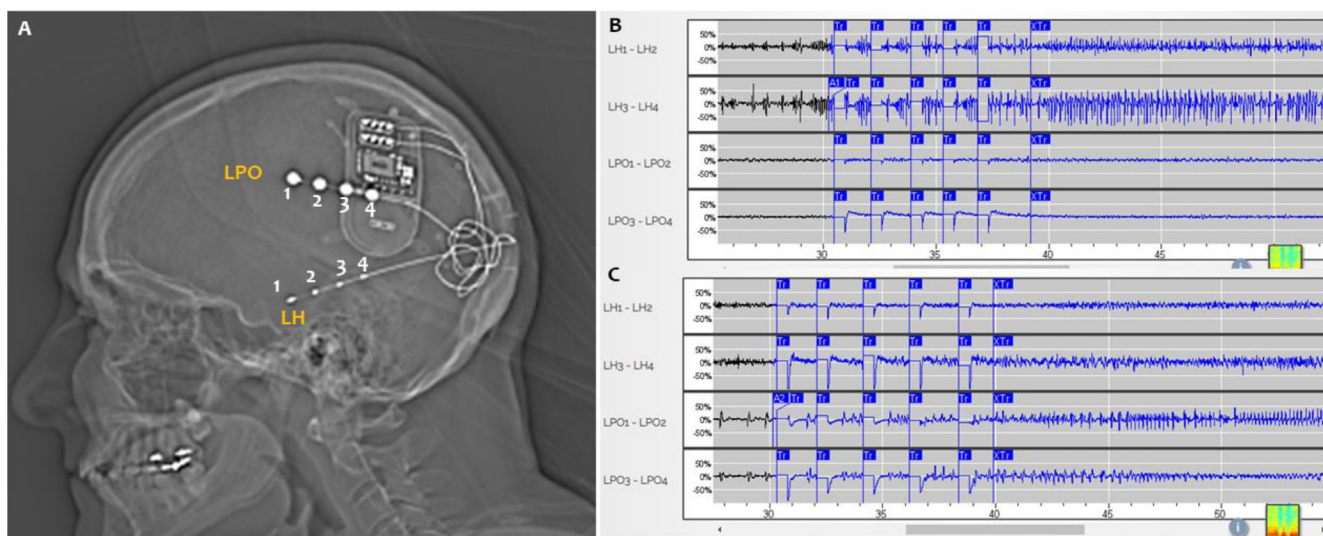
Sagittal head CT topogram showing the location of a left hippocampal depth and left parieto-occipital strip electrodes. ECoG example showing an electrographic seizure arising from the left hippocampal depth (LH3-LH4) [B] and left parieto-occipital strip electrode contacts (LPO1-2) [C]. *Tr = therapy.
